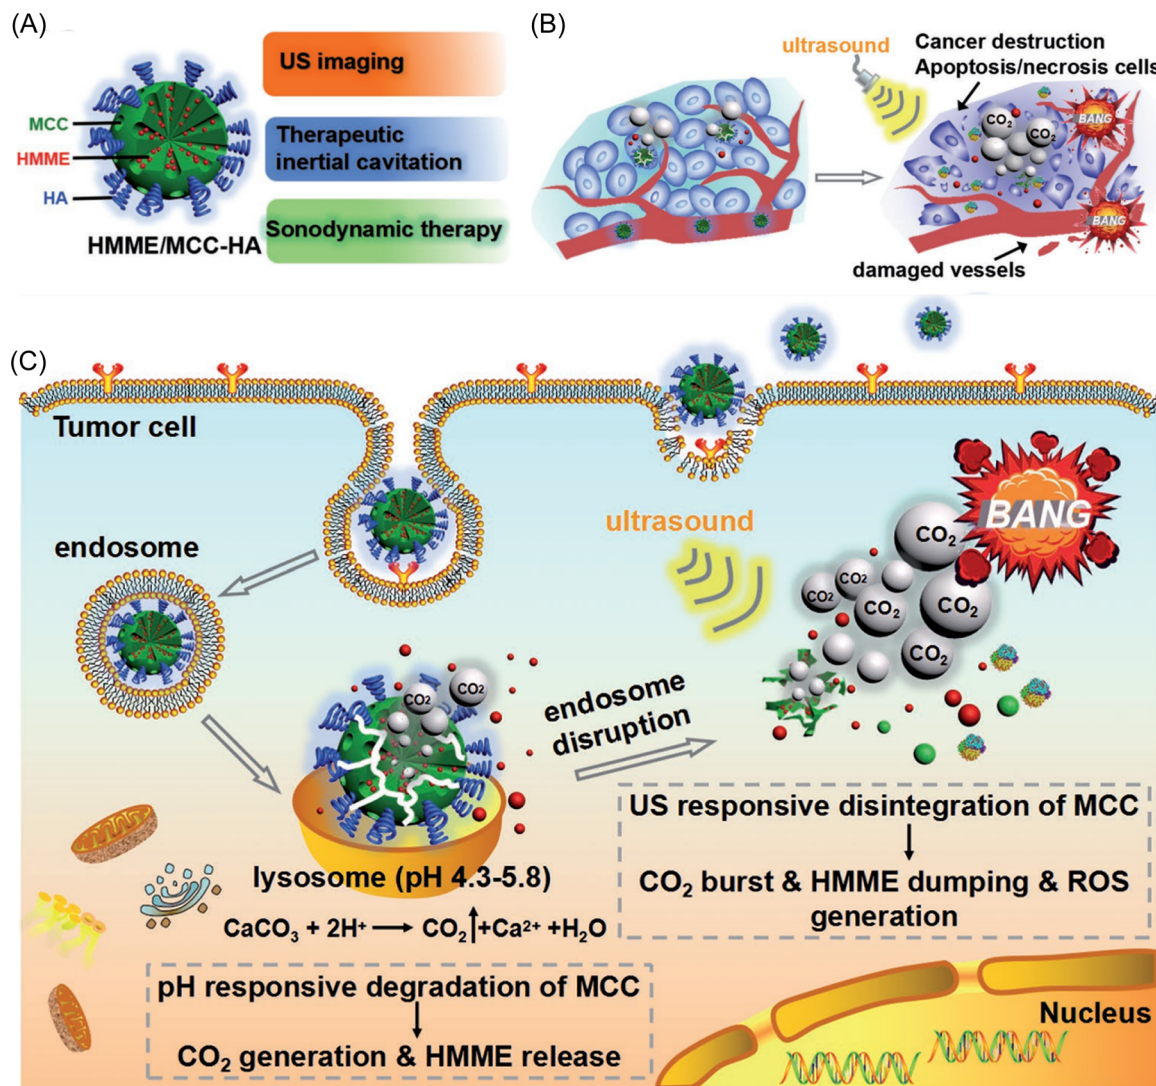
(A) The design of HMME/MCC-HA. (B) The mechanisms of causing cell death. (C) HMME/MCC-HA realized pH/ultrasound dual-responsive decomposition of MCC, CO₂ bubbling, and drug releasing behaviors in cancer cell, triggering cell death ultimately induce tumor cell death through ultrasound-activated synergistic therapy. Reproduced with permission from reference.¹⁰⁶ Copyright 2017, Wiley.
